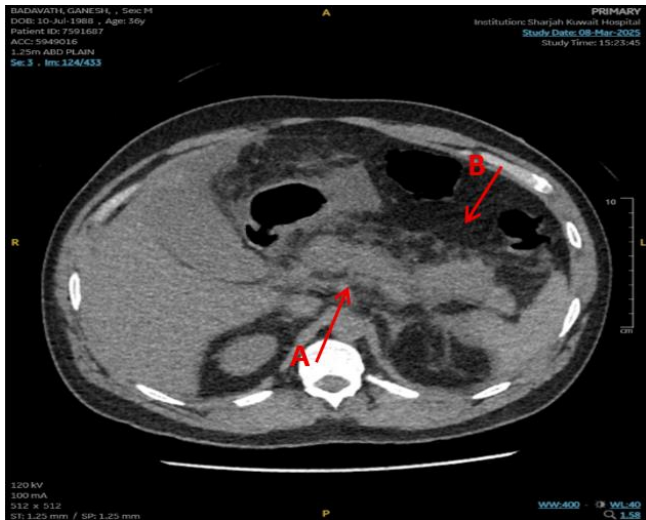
Axial section of CT scan showing bulky pancreas prominently at the head (Arrow A) surrounded by fat stranding and free fluid (Arrow B)
